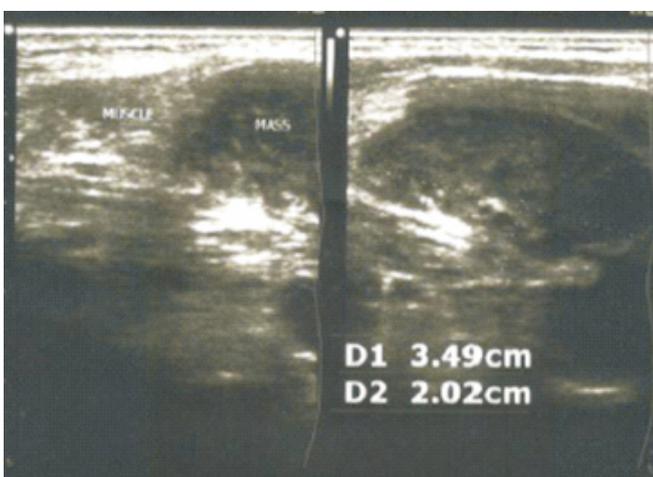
Neck ultrasound of neck showing cystic neck mass
